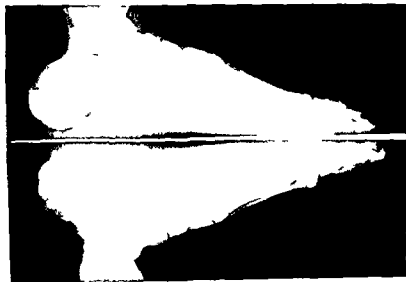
Radiograph of a 34-year-old woman with rheumatoid arthritis which began in 1961. Note marked sclerosis of distal artery of the foot.
